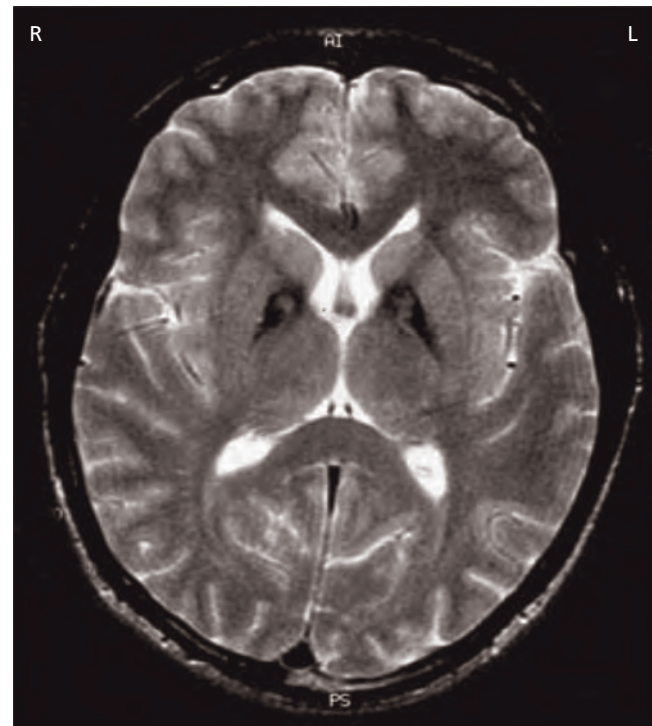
Classic ‘eye of the tiger sign’ (central hyperintensity with surrounding hypointensity in globus pallidus) in a patient with neurodegeneration with brain iron accumulation (NBIA) caused by a *PANK2* mutation (MRI T2W).
